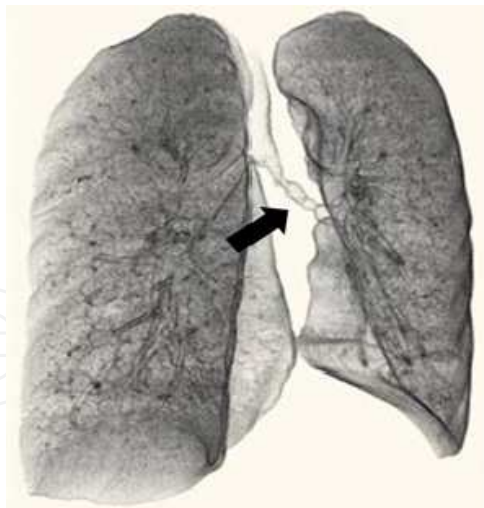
Tuberculous stenosis of the left main bronchus and left lower bronchus of a 30-year-old male (patient 8). He developed continuous stridor and cough. Three-dimensional reconstruction CT shows irregular luminal narrowing from the left main bronchus to the left lower bronchus (arrow).
